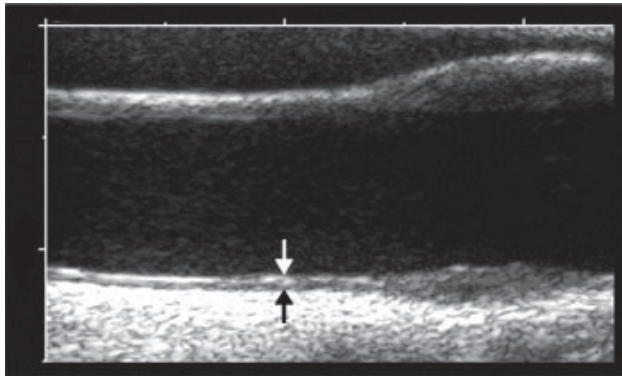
Intima-media layers (arrows) of the common carotid artery in an ultrasound image.*
